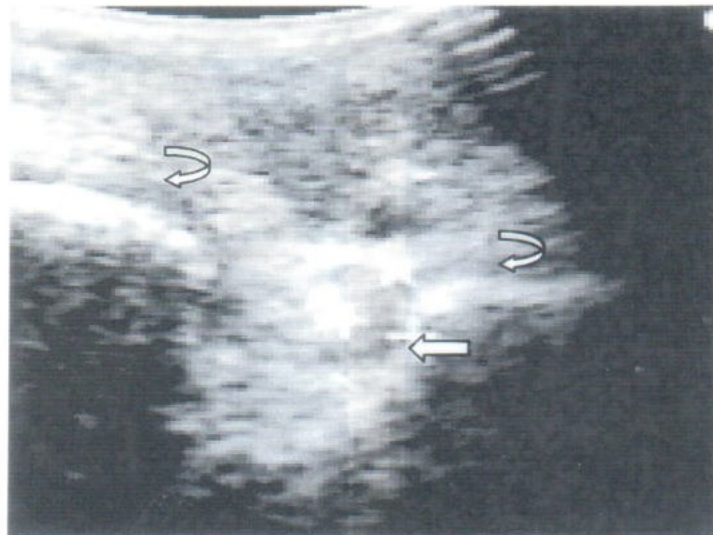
Case 1. Sonogram of right knee showed a 4.7x11 mm. hypoechoic collection at origin of right ACL (white arrow) and thickening of the hypoechoic synovium (curved arrow). The findings represented hematoma at ACL origin and joint effusion, respectively. Knee operation revealed midsubstance tear of right ACL and a hematoma at ACL origin.
